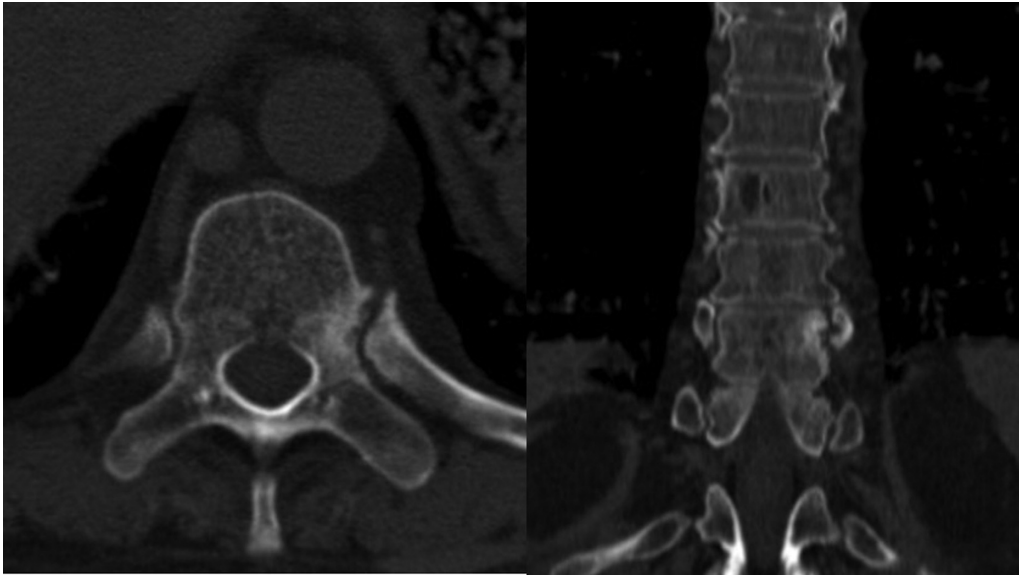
Computed tomography. Axial (left) and coronal (right) cuts. The 10th left costovertebral joint presents significant degenerative changes, with sclerosis at the levels of the vertebral body, pedicle, and rib head.
